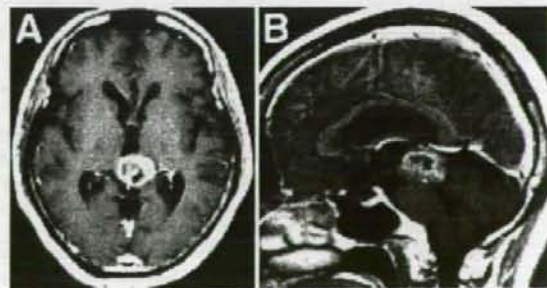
Axial (A) and sagittal (B) T_1 -weighted magnetic resonance images with contrast showing a heterogeneous enhanced mass in the posterior portion of the third ventricle.
